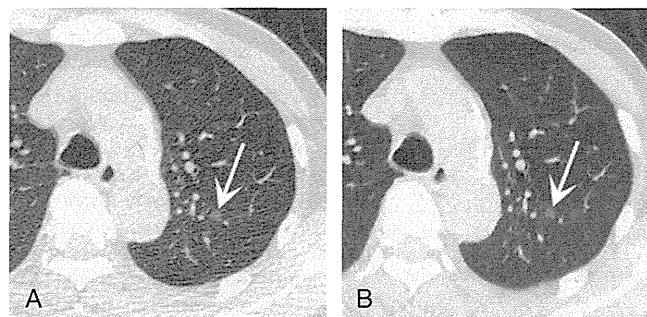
Imaging results of a 79-year-old man (weight, 64 kg): A, Low-dose CT (DLP, 64.2 mGy-cm) reconstructed with ASIR. B, Ultralow-dose CT (DLP, 15.4 mGy-cm) reconstructed with MBIR. The prominent streak artifact from the shoulders on the low-dose ASIR (A) interferes with the adequate visualization of the GGO nodule in the left upper lobe (arrow), which was missed by both radiologists. In the ultralow-dose MBIR (B), the nodule is clearly depicted (arrow) and was identified by both radiologists. The images are shown in lung window settings (WW, 1,500 HU; WL, -600 HU).
